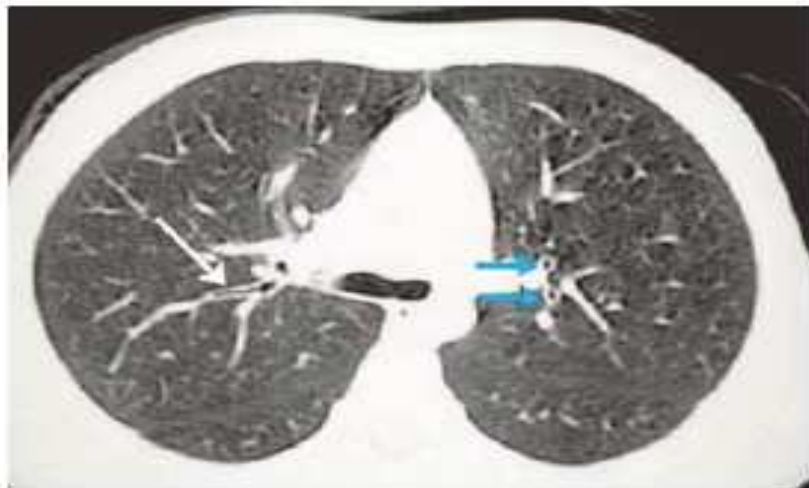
High-resolution axial CT of a 10-year-old boy demonstrating mildly dilated central airways (blue arrows) and mild peribronchial thickening (white arrow).
